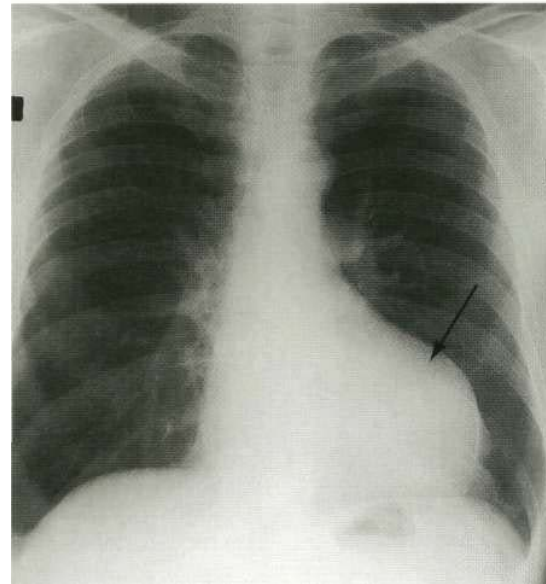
Left ventricular aneurysm: plain PA chest X-ray demonstrating a cardiac silhouette with a 'bulge' (arrow) on the left lateral border. This bulge is due to aneurysm formation of many years following a myocardial infarction. A thin line of calcification can be seen along the edge of this bulge.
